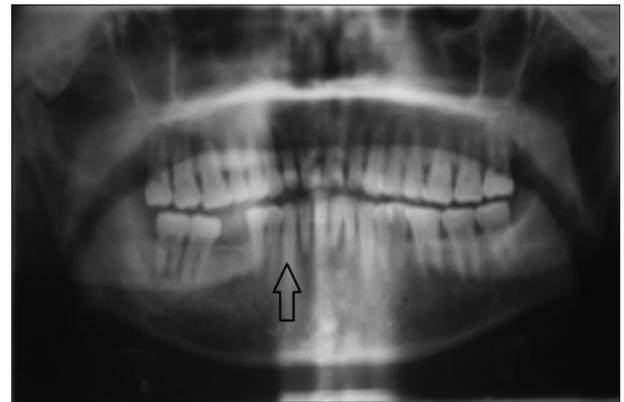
Panoramic radiograph reveals no bony involvement
